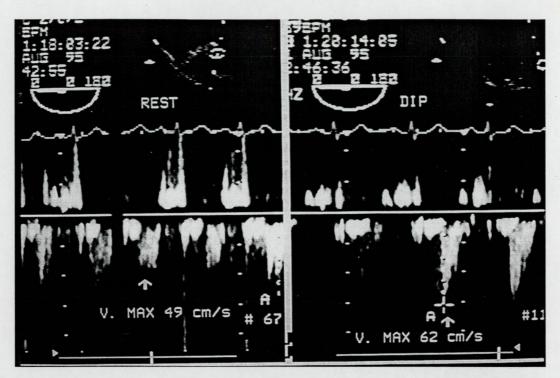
Measurement of regional flow reserve in a patient with dipyridamole-induced inotropic response in a region with baseline resting dysfunction. The pulsed Doppler flowmetry at baseline (REST, left panel) shows a normal bifasic, mostly diastolic, flow with a peak flow velocity of 49 cm/s. Following infra-low dose dipridamole (dipyridamole, right panel), there is an obvious increase in peak diastolic flow velocity, reaching 62 cm/s, with a 26% increment over baseline.
